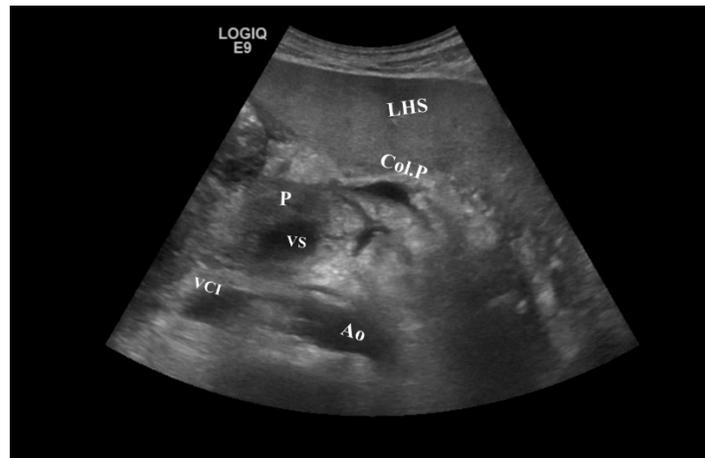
Acute suprapancreatic fluid collection – ultrasound appearance.
